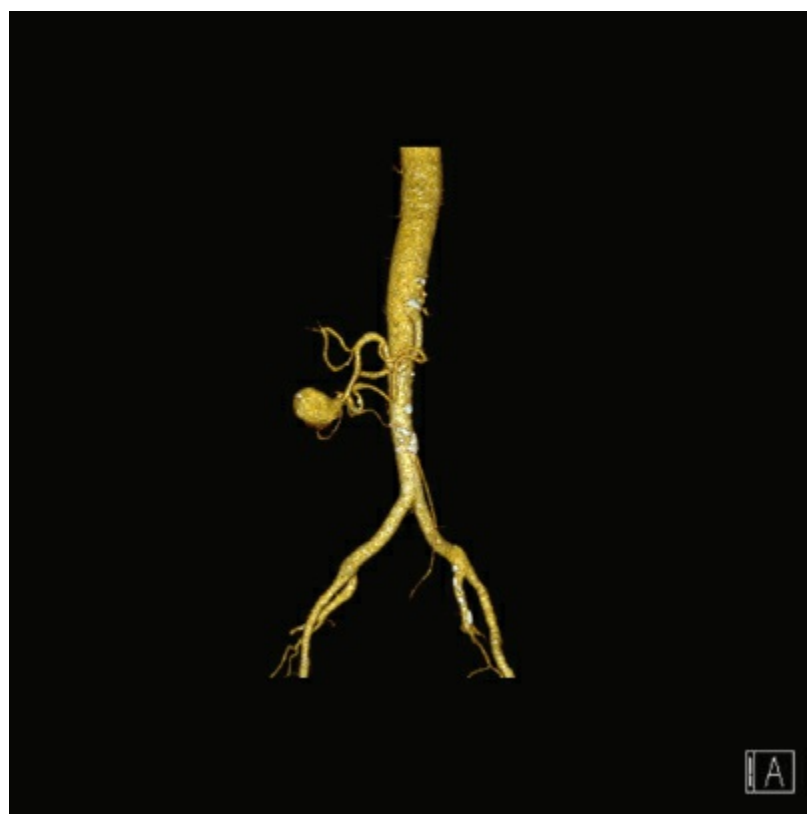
CT angiogram of an 87-year-old woman with a large 3.4-cm gastroduodenal artery aneurysm associated with celiac artery occlusion.
